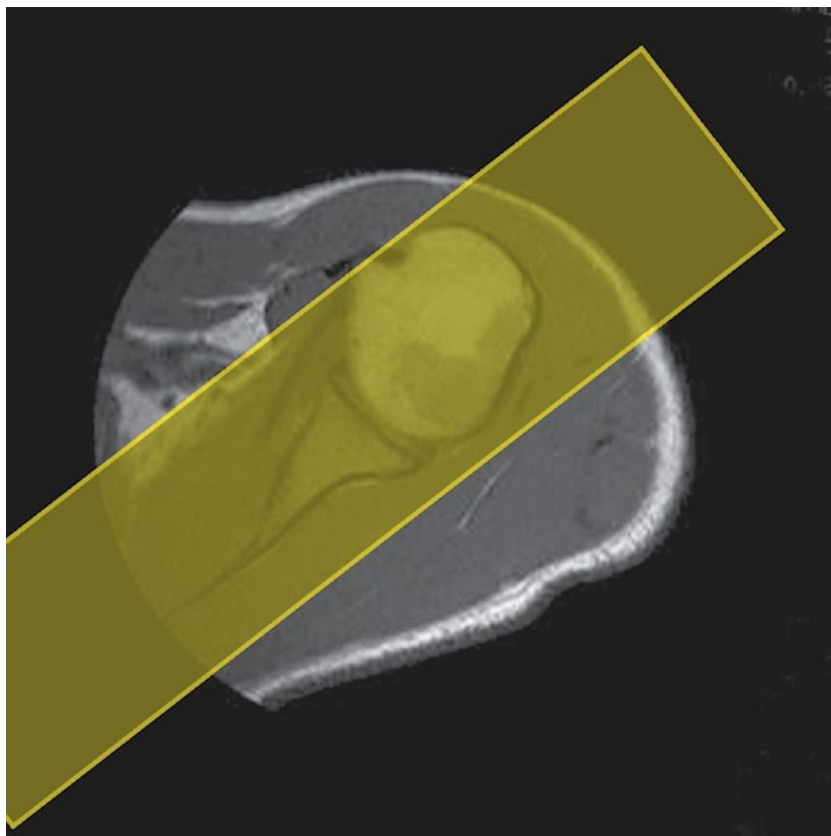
Coronal/oblique T1-weighted FSE through the shoulder.
